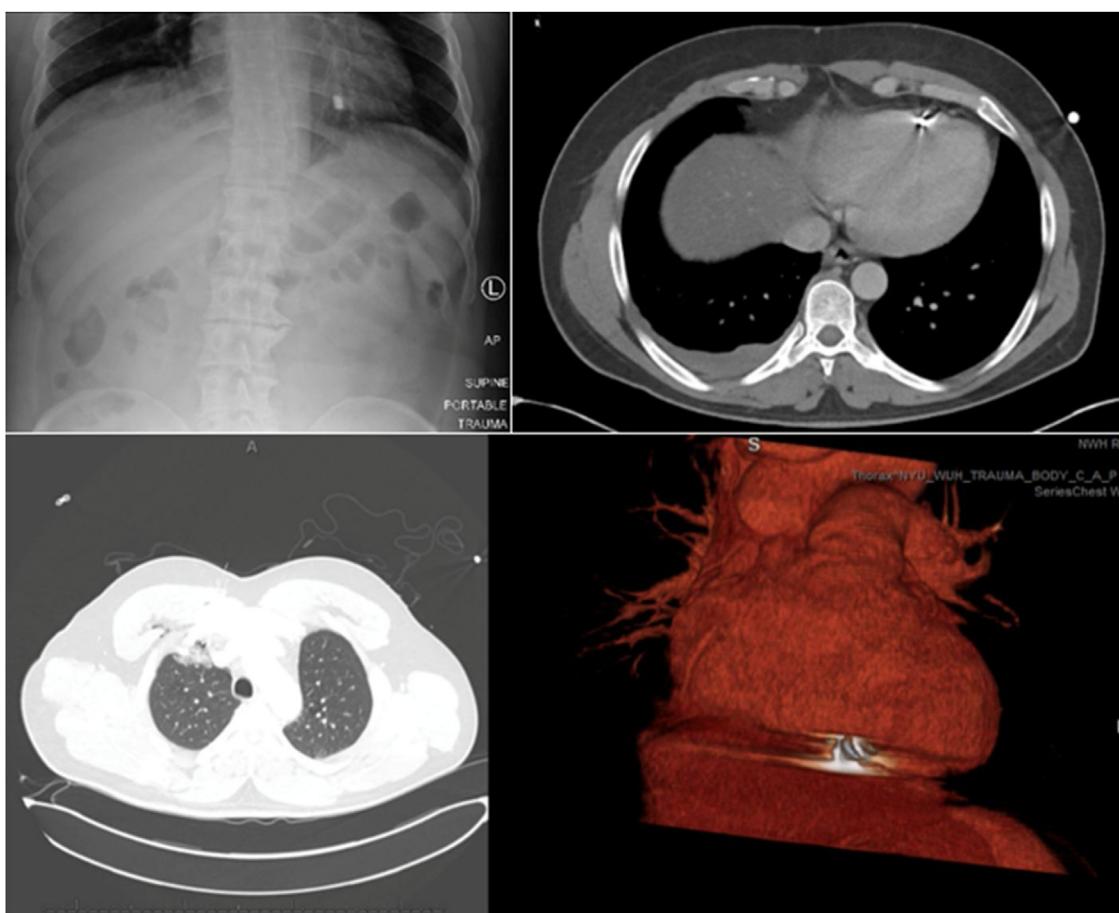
Preoperative radiographic studies attempting to localize bullet. 2a. Chest x-ray showing hyperdensity (bullet) sitting to left of midline. 2b. Axial CT with bullet anterior to intra-ventricular septum. 2c. Axial CT with bullet track through anterior chest wall, and lung parenchymal contusion in region of the SVC. 2d. 3D reconstruction of bullet between inferior border of heart and diaphragm.
